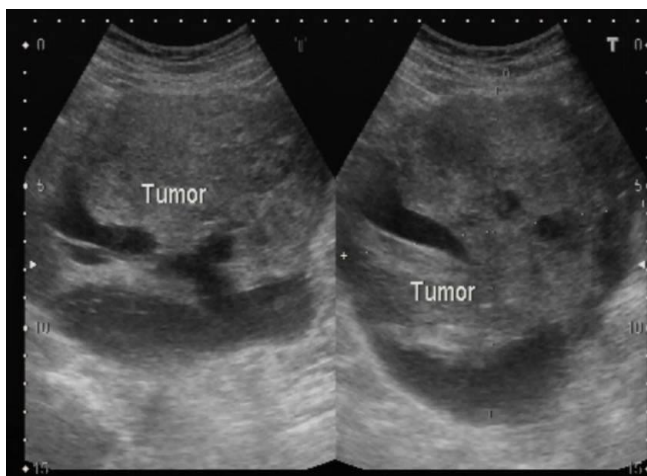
Ultrasonography revealed a hypoechoic heterogenous tumor in the abdomen.
